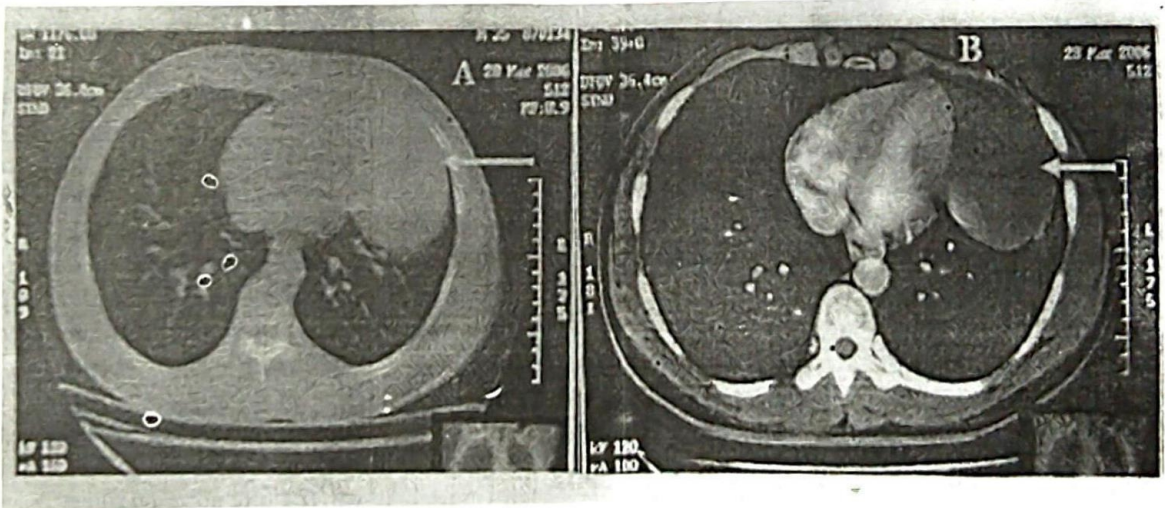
Computerized tomography (CT). A = pre-contrast picture, B = post-contrast picture. Arrow points to the cyst.
